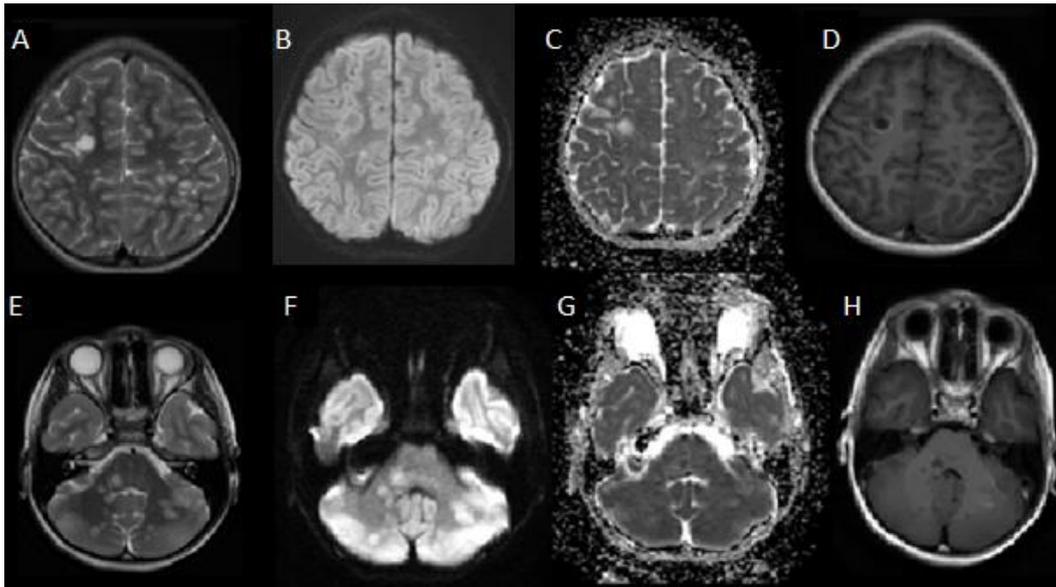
Distribution of lesions on MRI A, Axial T2-weighted image of supratentorial area. B, Axial Diffusion-weighted image of supratentorial area. C, Apparent Diffusion Coefficient image of supratentorial area. D, T2-FLAIR post-contrast image of supratentorial area. E, Axial T2-weighted image of posterior fossa section. F, Axial Diffusion-weighted image of posterior fossa section. G, Apparent Diffusion Coefficient image of posterior fossa section. H, T2-FLAIR post-contrast image of posterior fossa section.
